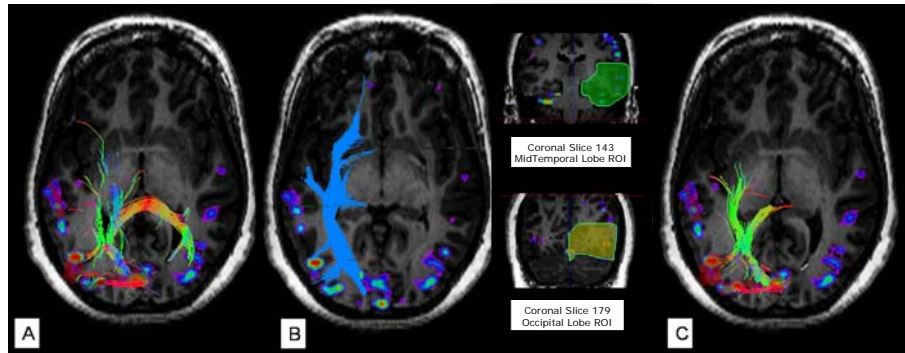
MEG imaged coherence of spontaneous cortical activity overlaid on the volumetric MRI of Patient # 7. Coherence scaling shown as low to high on blue to red color scale. A. Superior view of fibers tracked from ROI bounding high coherence in right parietal lobe. All views are radiologic convention. B. Inferior Longitudinal Fasciculus (ILF) tracked with the standard two ROI method between the MidTemporal and Occipital lobes shown inset [9, 10]. C. Inferior view of same fibers from view A. Areas of high coherence are linked with fibers from the ILF as well as occipital projections of the callosal fibers.
